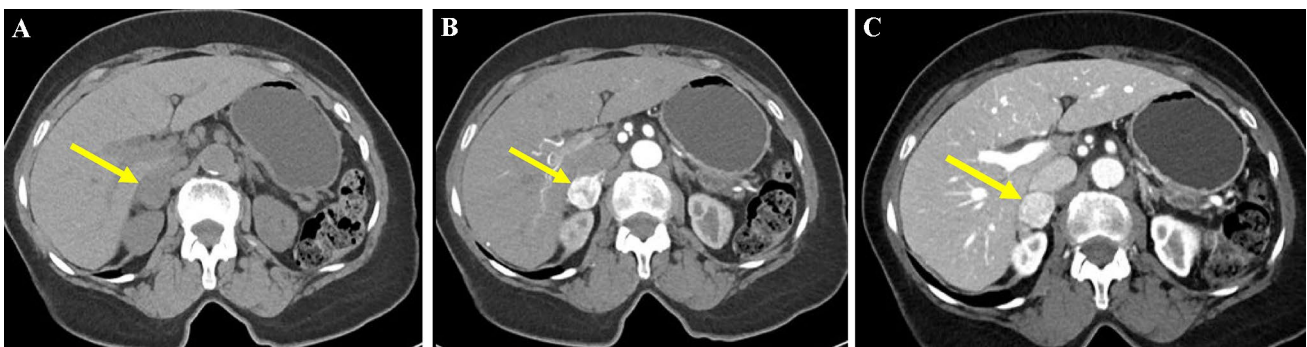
Hypervascular right adrenal pheochromocytoma on dual-phase CT. Axial noncontrast (A), arterial phase (B), venous phase (C), CT demonstrate a 2.5 cm right adrenal mass (arrow) with attenuation of 31 HU on precontrast phase, 190 HU on arterial phase, 256 HU on venous phase
